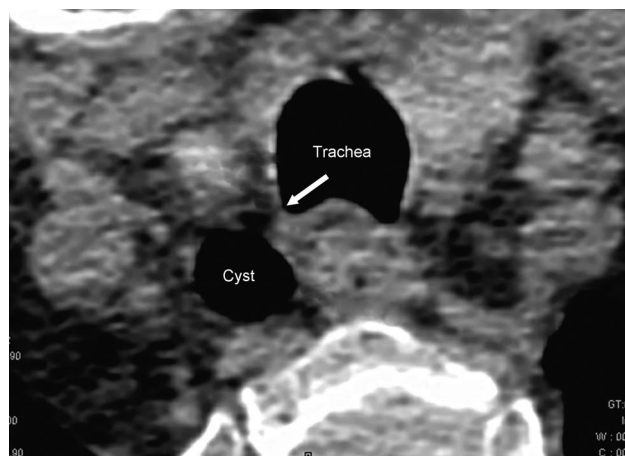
Axial computed tomography scan of the upper thorax shows a thin-walled air cyst located posterior to and right of the trachea, with connection to the trachea (arrow).
